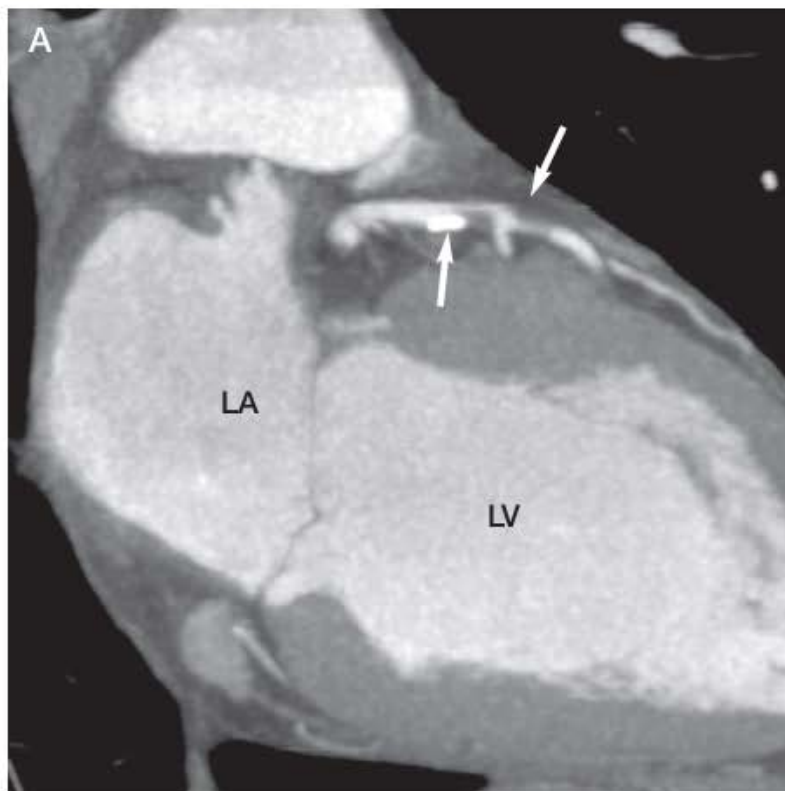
Tandem high-grade coronary artery stenoses (*arrows*) in left anterior descending artery, proximal and distal to a diagonal branch. *A*, Coronary computed tomographic angiogram, reformatted in vertical long axis. *B*, Invasive selective coronary angiogram. LA, left atrium; LV, left ventricle.
